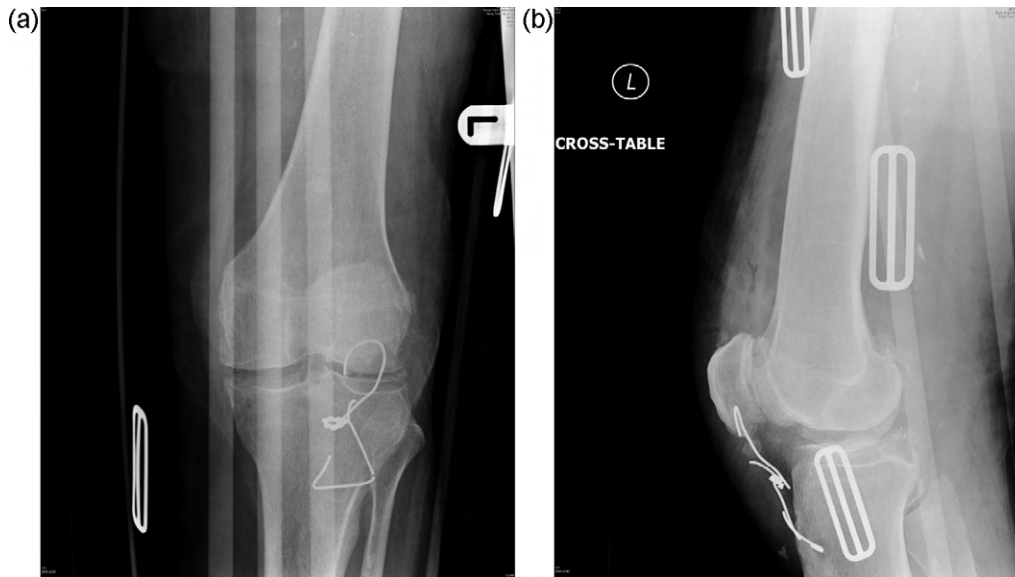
Post-operative (a) anteroposterior and (b) lateral radiographs of the knee showing reduction of the patella.
